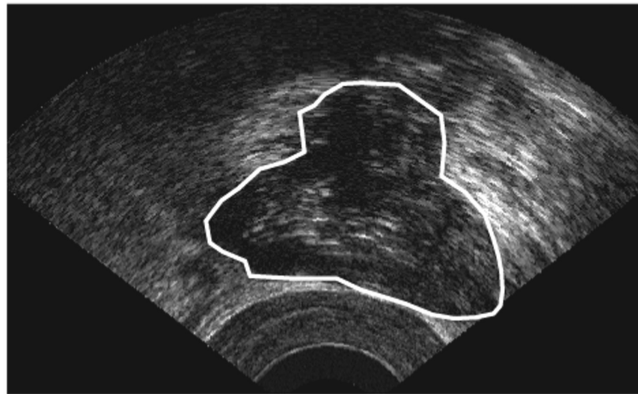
shows an example ultrasound image of the prostate obtained at apex, mid-gland, and base regions.■
